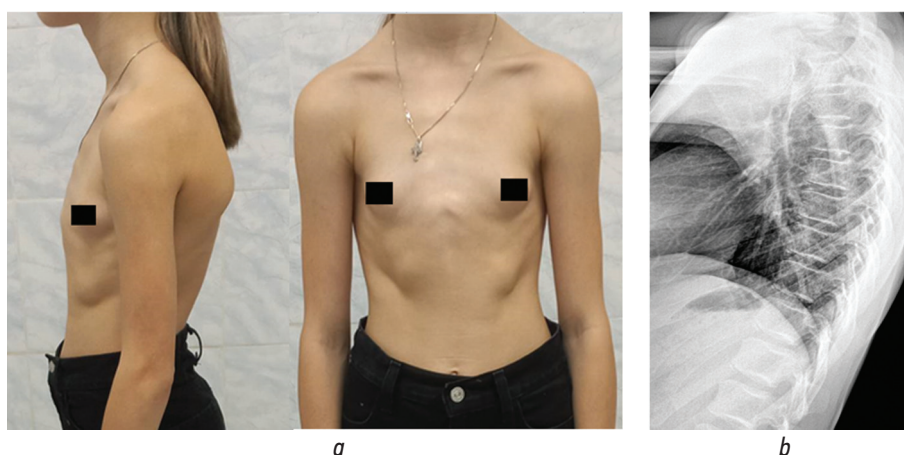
Appearance (a) and radiographs (b) of a 12-year-old child with pectus carinatum, kyphotic posture, and pterygoid protrusion of the shoulder blades. Some signs of osteochondropathy do not meet the criteria of Scheuermann's disease (apophysial necrosis and usuration of the vertebral bodies' endplates without their wedge-shaped deformation) on lateral radiographs
